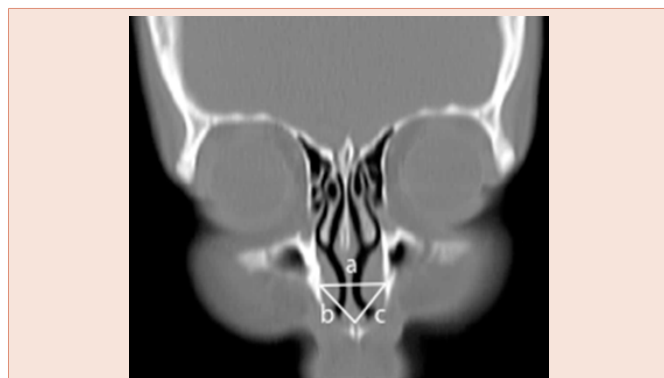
Shows the measurements of the angle of the septal deviation (ASD) and the maximal height of orbit (AB) on coronal CT image.
